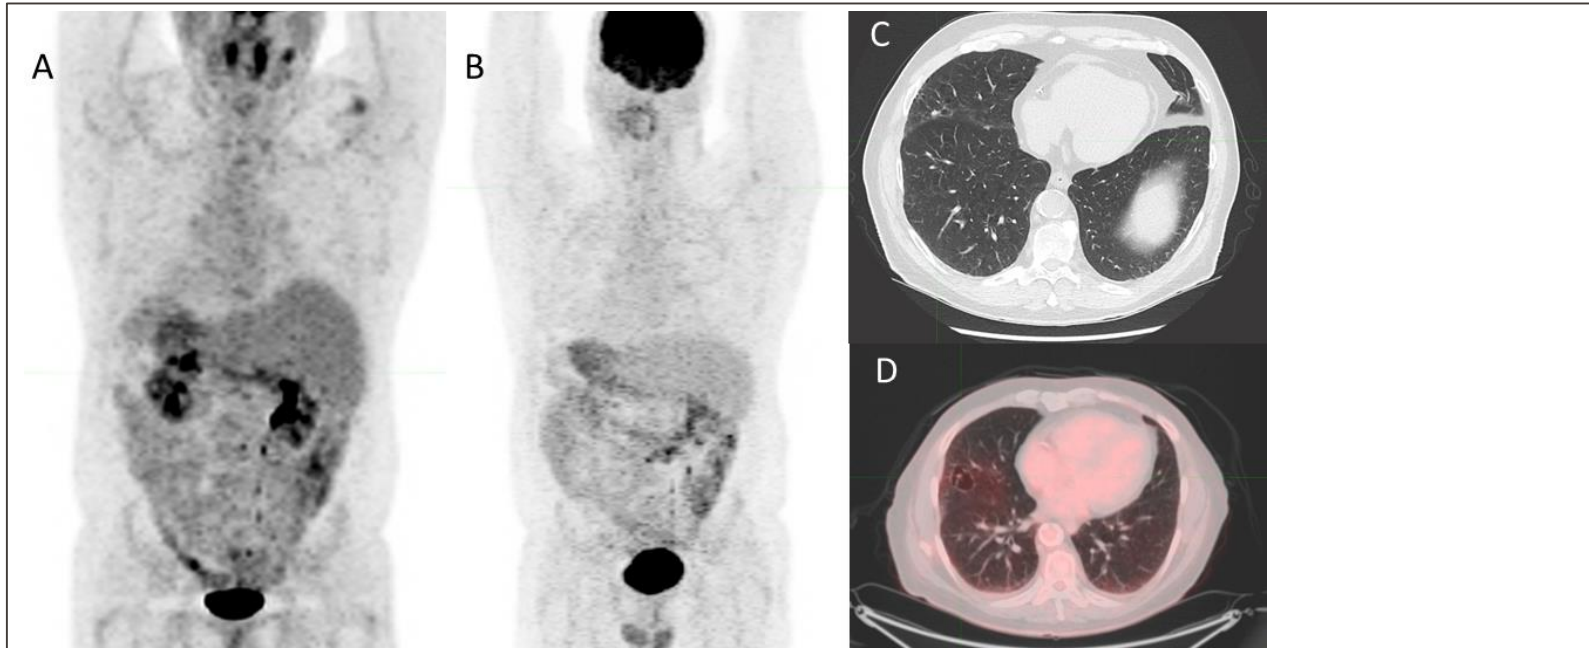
Images of 62 years old male with HL who subsequently developed lung cancer after treatment A: Baseline PET scan showing FDG-avid uptake in right-sided level II cervical nodes. No other nodal or extranodal FDG-avid lesions identified on the current scan. B: post treatment PET scan showing no evidence of FDG-avid disease. C: A low dose CT chest without contrast after 13 years showing new 6 mm nodule in the middle lobe D: An axial cut of PET CT fusion showing middle cavity associated nodule that was biopsy-proven to represent tumor is not FDG avid.
